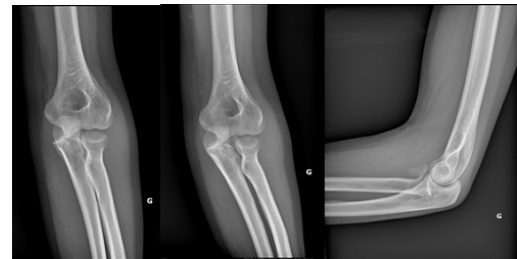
Anteroposterior and lateral X-rays of the left elbow demonstrate a bony fragment lying in the left ante-cubital fossa and a postero-medial subluxation of the left elbow.
